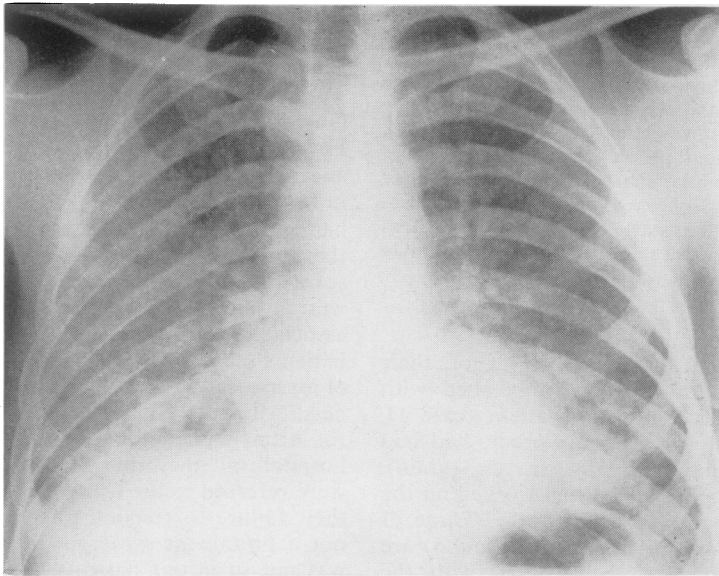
Case 6. Nodular infiltration in the mid and lower zones of both lungs with more confluence at the bases. Radiograph taken 12 days after leaving work on a mushroom farm.*
